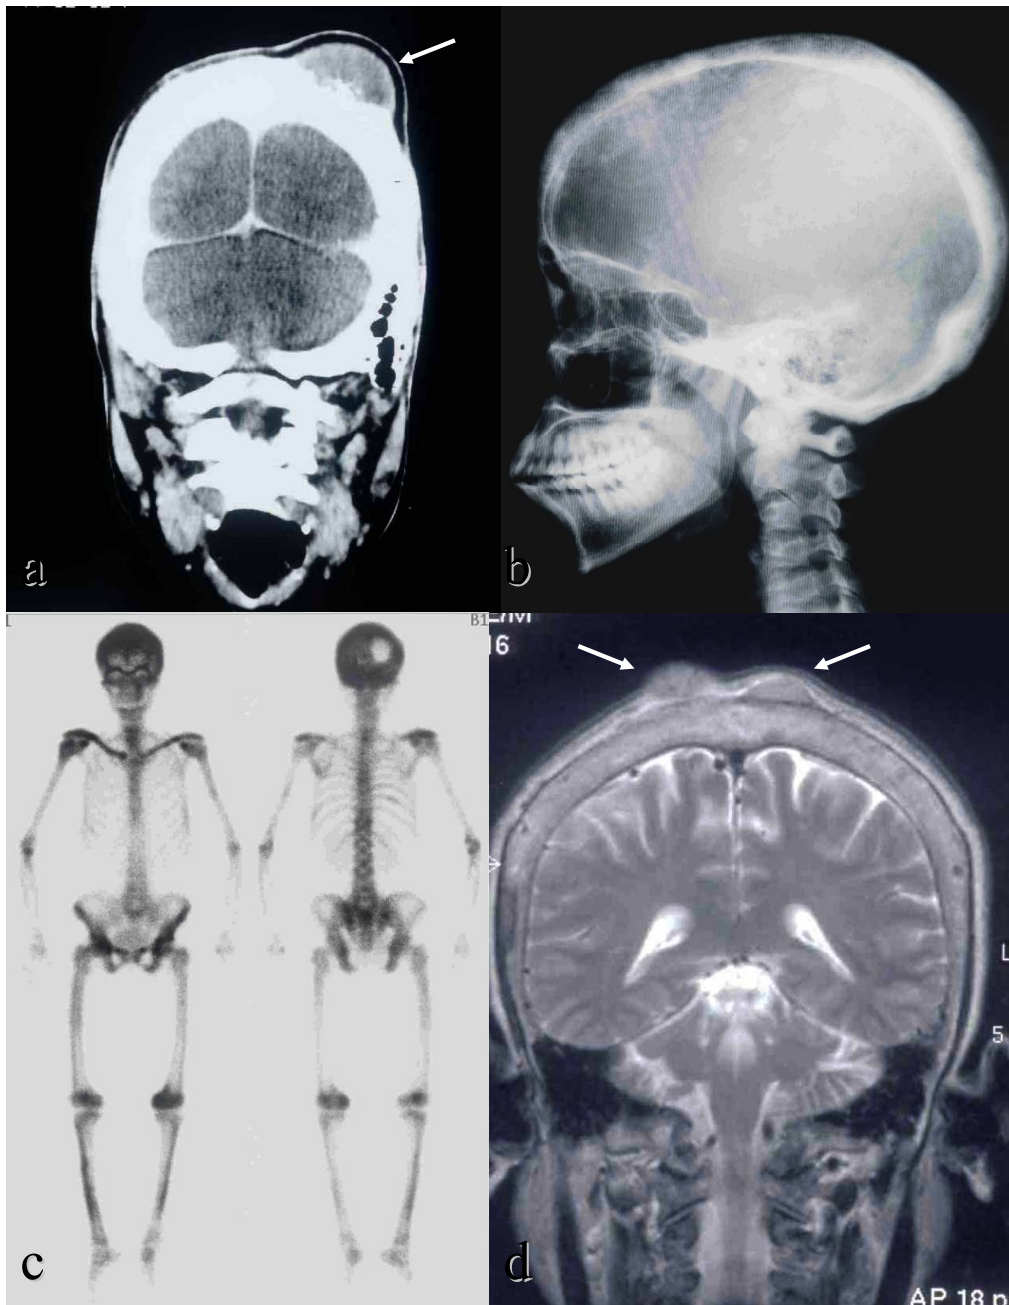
a) Coronal soft tissue window computed tomography scan images shows giant cell tumor of the left occipital bone affected with paget's disease of bone seen at the first visit (allow).
